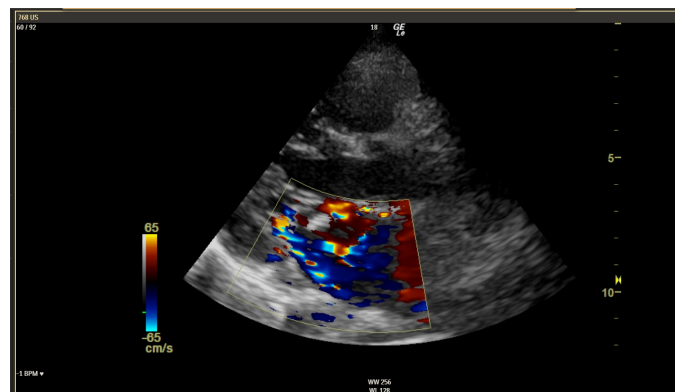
Transthoracic echo before the operation showing significant mitral regurgitation by colour Doppler.
